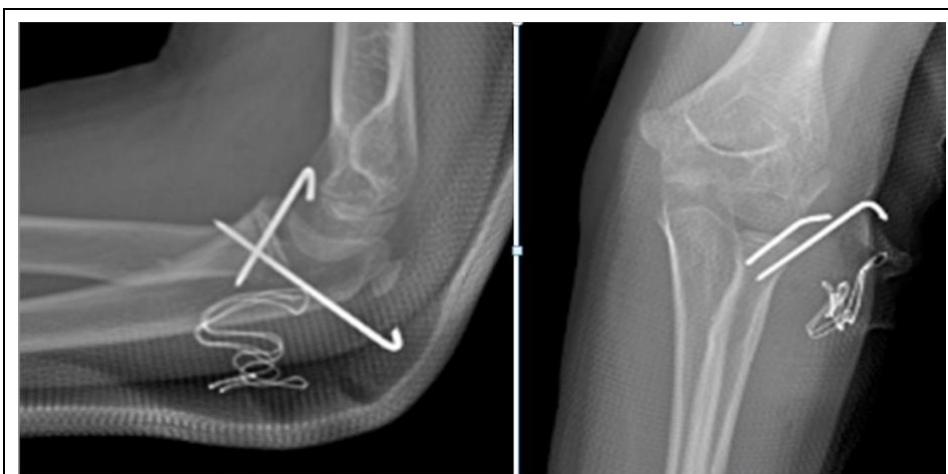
Postoperative X-ray image shows radius head with percutaneous Kirschner wire.
